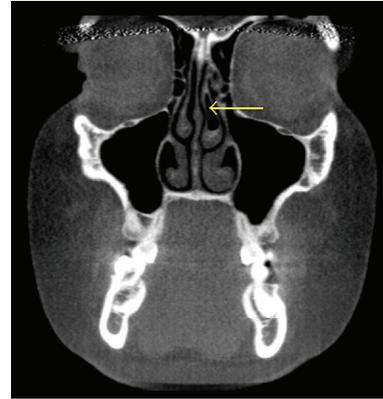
Coronal CT scan demonstrating the presence of left middle concha bullosa (arrow). No septal deviation or sinusitis is present. Note the size difference in the middle conchae, with the left middle concha larger than the right middle concha.
